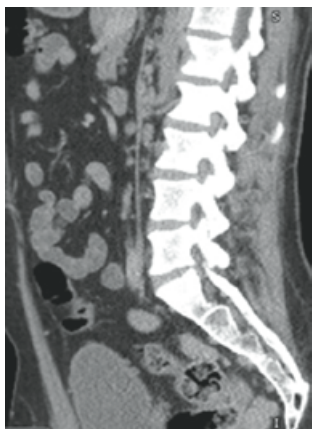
CT venogram demonstrating chronic IVC occlusion.
